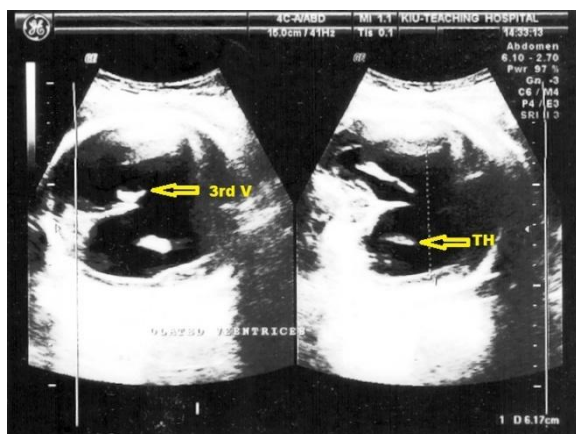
The sonogram shows extensive fetal ventricular dilatation with complete displacement of brain matter. The AP diameter of the lateral ventricle measures 6.74 cm. Note the floating part of the tentorium cerebri. Focused trans-ventricular ultrasound indicates the arrowed third ventricular (3rd V) and thalamus (TH).
